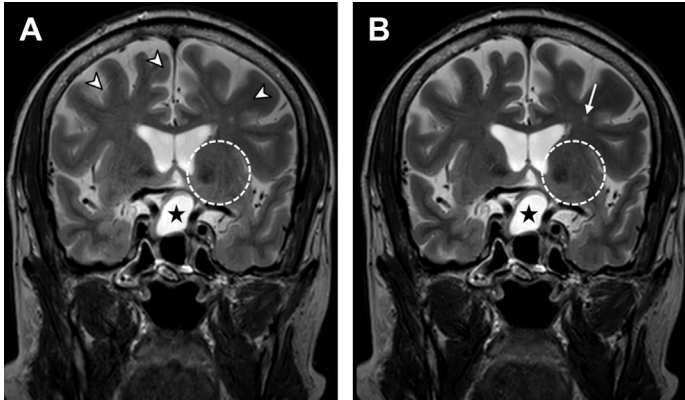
Comparison of sensing (SENSE) and compressed sensing (C-SENSE) accelerated T2-weighted images. (A) is acquired using regular SENSE, with 2:30 min scan time. (B) uses C-SENSE, with 1:26 min scan time. Mild motion artifacts are seen in (A) (*arrowheads*), which are reduced in (B). The overall appearance of the basal ganglia is more consistent in (B) (compare the circled areas). The size and signal characteristics of the small white matter lesion in the left frontal lobe is unchanged (B, *white arrow*). The intrasellar-suprasellar cystic abnormality (*asterisk*) and the parasellar structures show the same signal and edge definition on the 2 scans. The overall clinical diagnostic utility is not affected by using C-SENSE.
